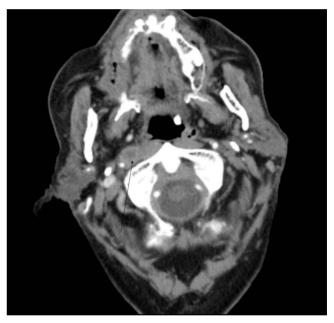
Axial contrast-enhanced CT showing a necrotic right retropharyngeal node (black arrow) in a patient with a hypopha-ryngeal posterior wall tumour.
